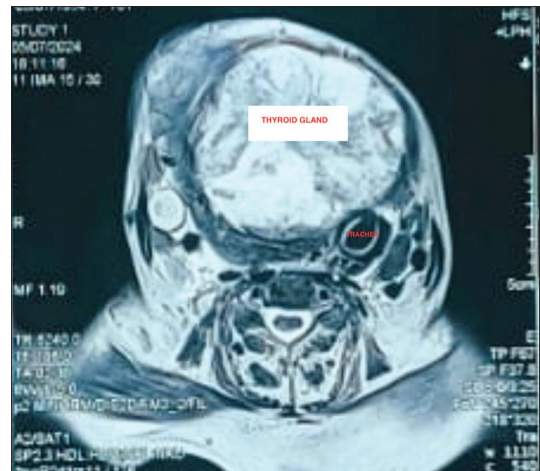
Magnetic resonance imaging neck showing trachea shifted to the left
